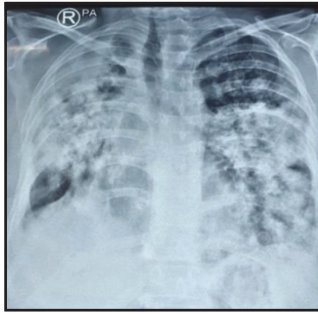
Chest X-ray PA view reveals bilateral consolidation, nodule with cavitations.
